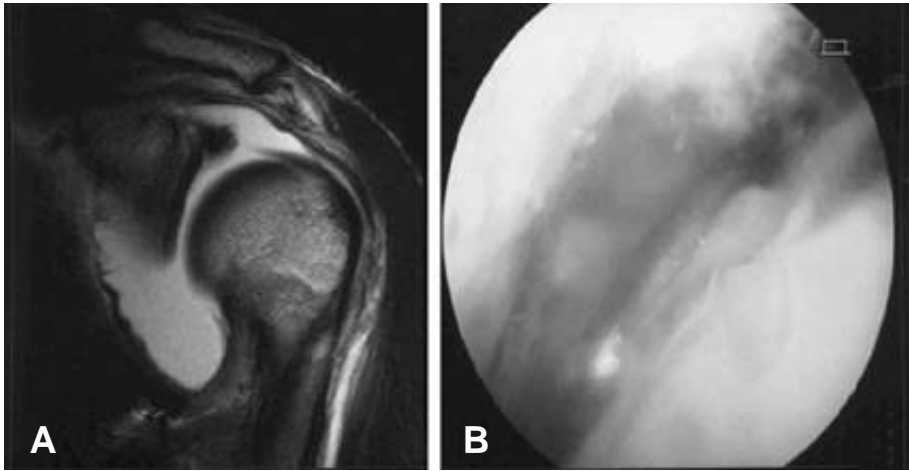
A 23 years old man had infection of the glenohumeral joint after contrast injection. Coronal T2W MR image reveals increased joint fluid with high signal intensity in the deltoid. Cartilage and bone marrow signal are normal(A). Arthroscopy at this stage visualizes cloudy joint effusion with snow storm like appearance because of cell debris and necrotic tissue, which corresponds to stage I(B).
